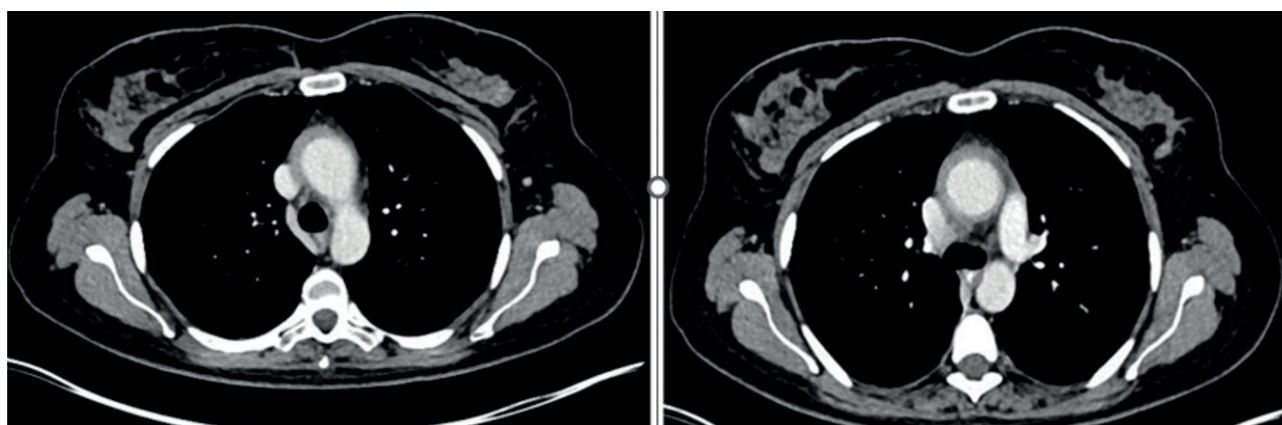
Axial CT scans acquired during the venous phase show concentric wall thickening of the aorta characterized by an internal hypoattenuating ring.
